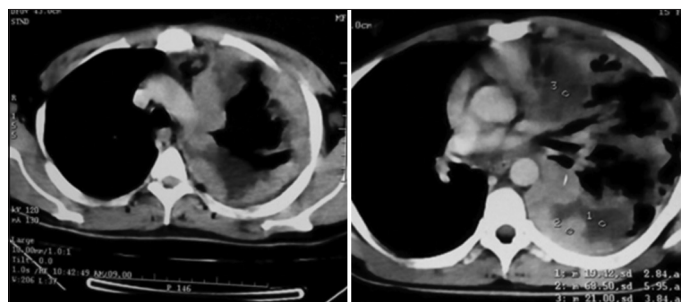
Axial section of contrast-enhanced computed tomography of thorax showing circumferential beaded growth
